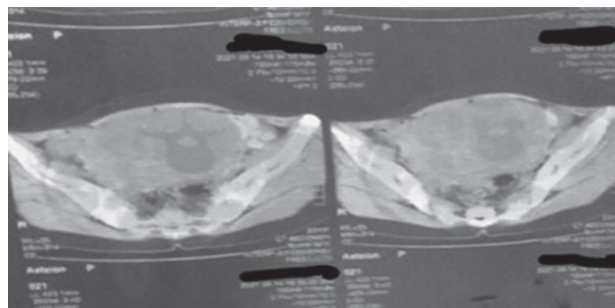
CT scan showing a huge hypo dense mass.
